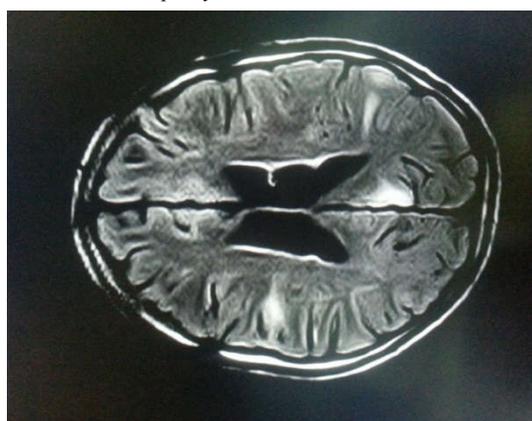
MRI of brain revealed multiple cortical tubers
